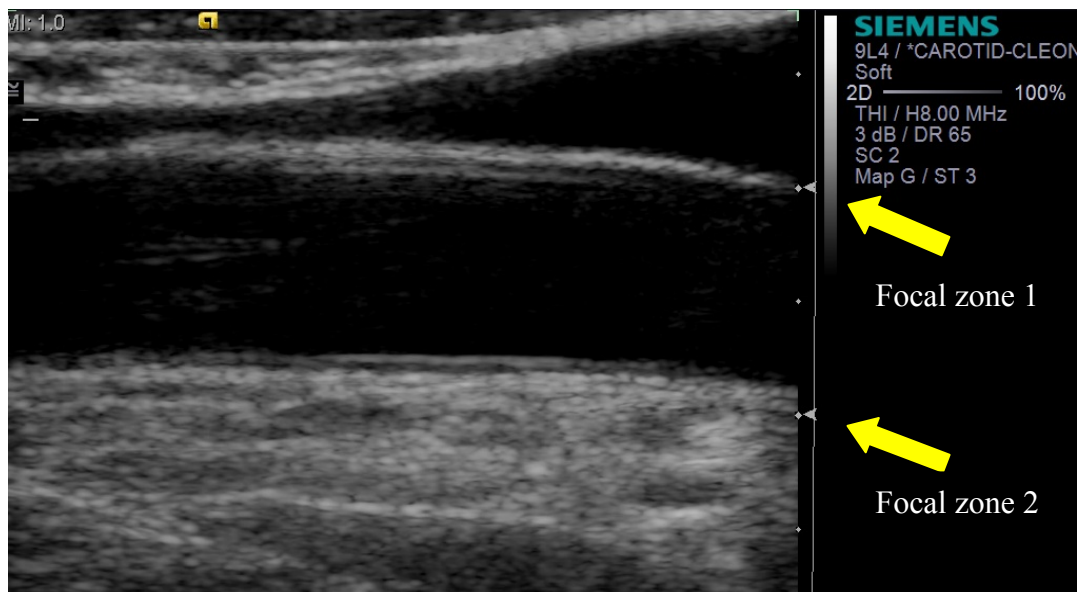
Focal zone of an ultrasound beam
